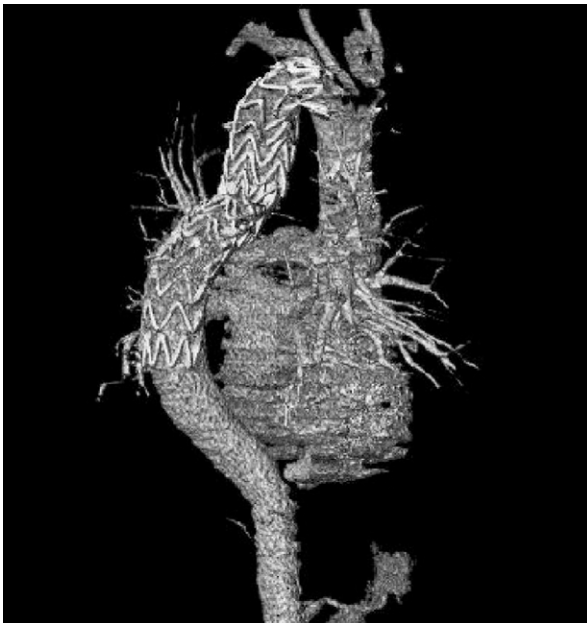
Postoperative computed tomogram (3-dimensional volume-rendered reconstruction) of the thoracic aorta shows complete thrombosis of the aneurysmal sac.
